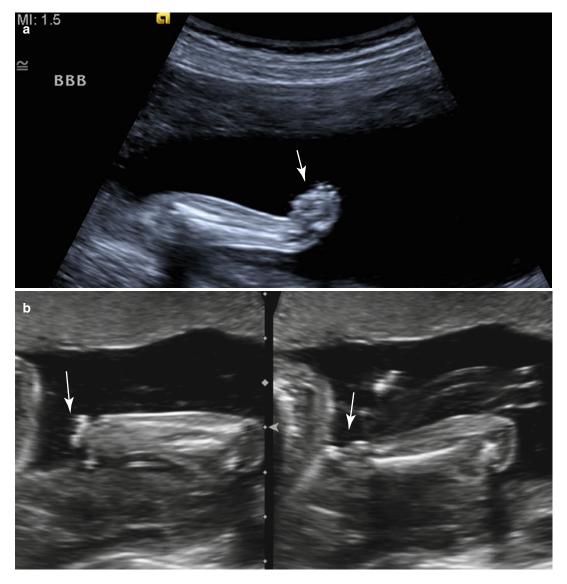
Prenatal sonograms at 20 weeks gestation showing two examples of transverse deficiency at two different levels, mid hand (a) and wrist (b)
